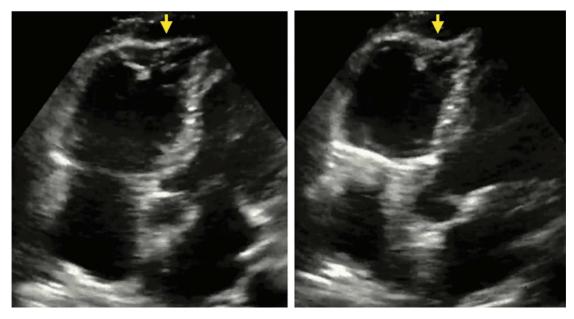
Apical five chamber window with arrow pointing to RV apex at diastole (L) and systole (R).
